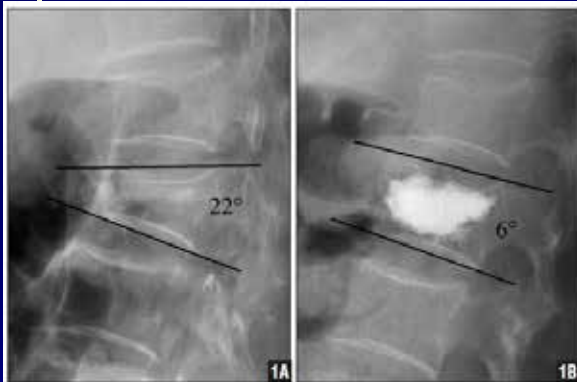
Pre- (A) and postoperative (B) lateral radiographs of a 71-year-old woman with an L1 vertebral compression fracture who was treated with kyphoplasty 2 weeks after acute and debilitating pain showing that the kyphotic angle improved from 22° to 6°, respectively. T-score was -3.8 SD.
